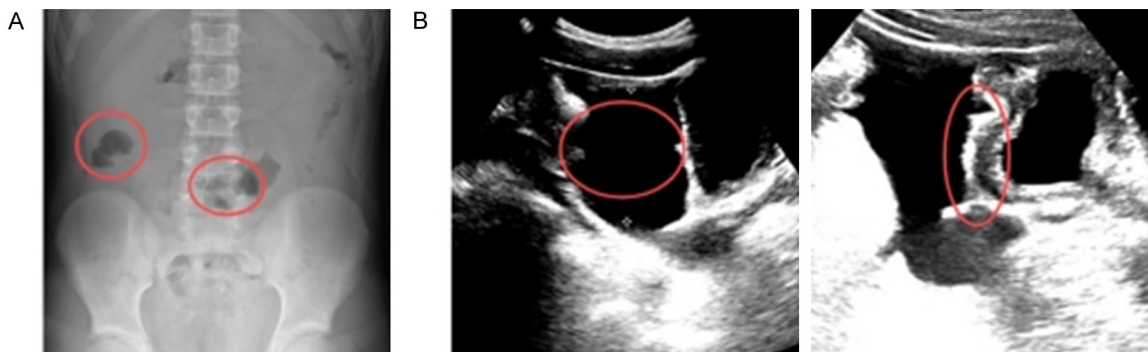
Imaging evidence of the child with eosinophilic gastroenteritis (A: Plain abdominal X-rays in the standing position; B: Abdominal B-ultrasonography).
